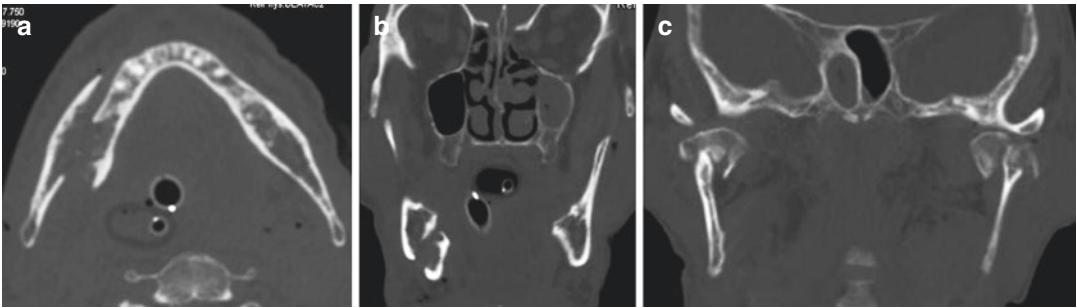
CT scans showing a displaced longitudinal disruption of the right mandibular body (a, b) associated with bilateral condylar fractures (c)
